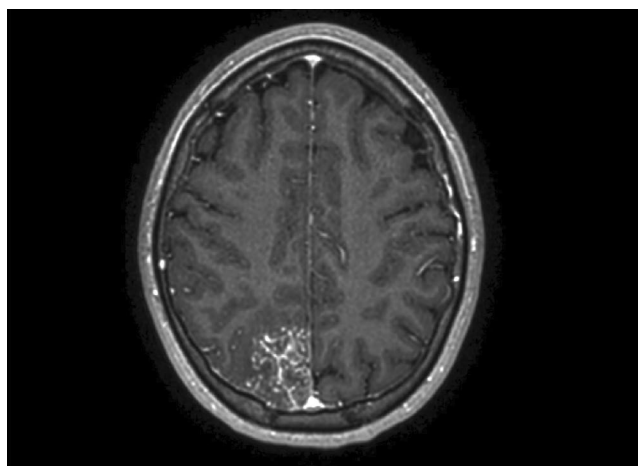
Brain MRI in axial T1
